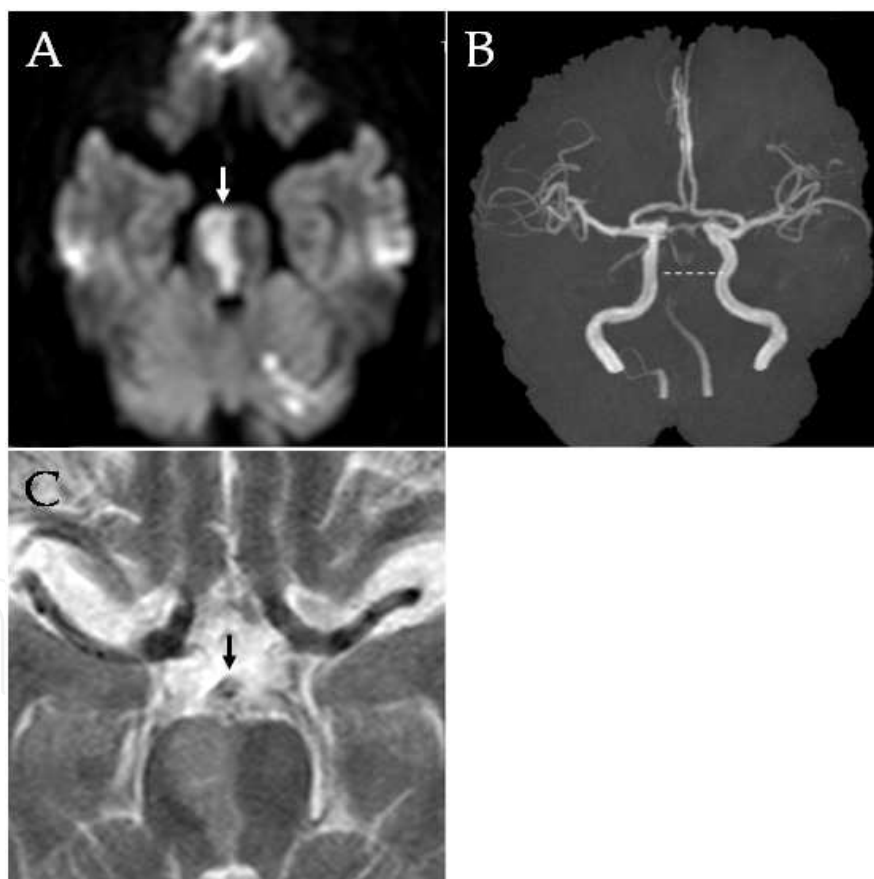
Basilar artery plaque image using 1.5 tesla magnetic resonance imaging scanner. A: Axial diffusion-weighted image demonstrating a right paramedian pontine high-intensity lesion (arrow). B: Magnetic resonance angiography showing severe stenosis of the basilar artery. C: T2-weighted image at the level of the dotted line on B (TR/TE 3500/100, matrix size 254×320), presenting plaque on the vessel wall (arrow).
